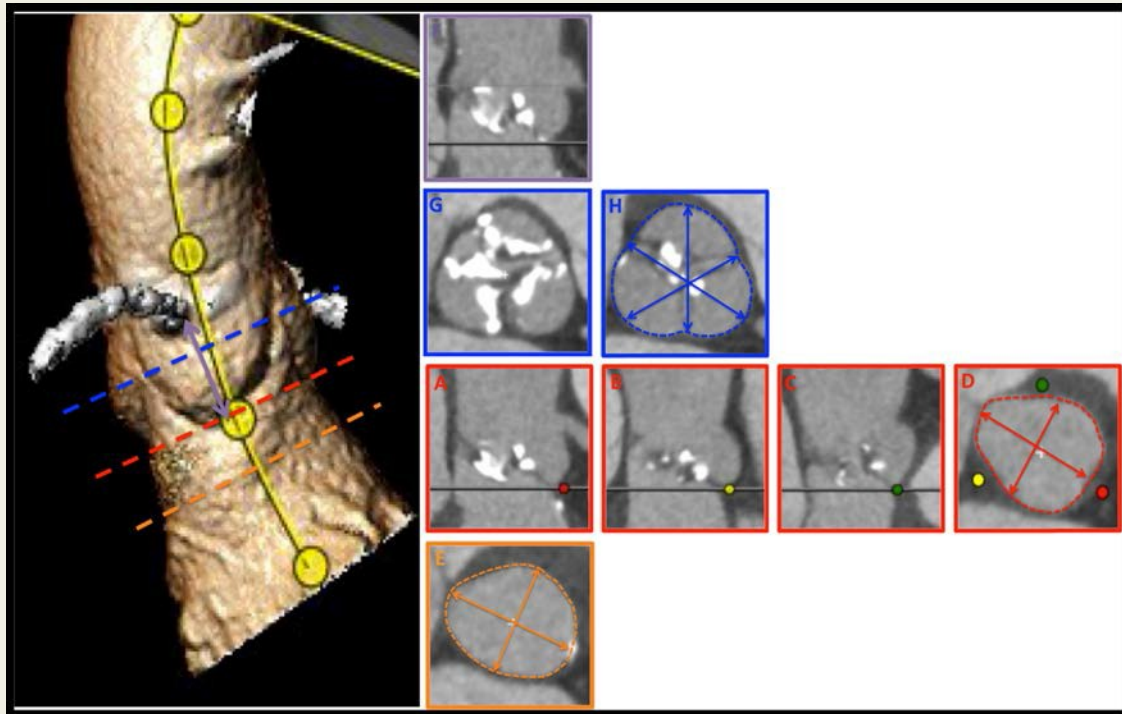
3-dimensional multi-detector row computed tomographic assessment of the entire aortoventricular interface is important in accurate sizing to ensure safe and effective transcatheter valve implantation. The nadir of each coronary cusp is identified (A, B, C) and the basal plane identified (D). Measurements are then taken along the centre line, in relation to the basal plane, at the level of the left ventricular outflow tract (E), coronary ostia (F), and sinuses of Valsalva (G, H).
